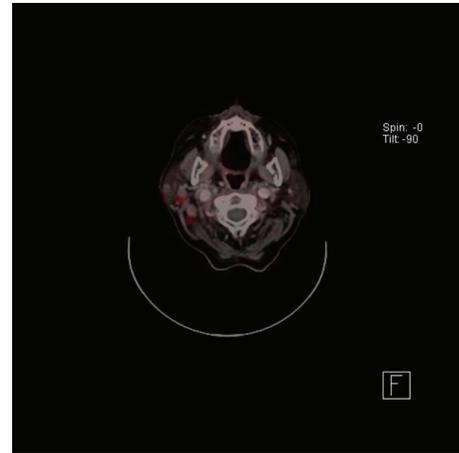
PET/CT: pathologic enhancement in the right parotid region.
